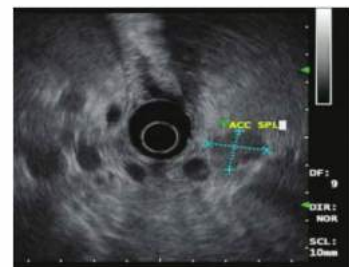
• Endoscopic ultrasound image of the same patient in FIG 2. The insulinoma is oval shaped and hypochoic. The gastroenterologist has incorrectly labeled the insulinoma as accessory spleen.
